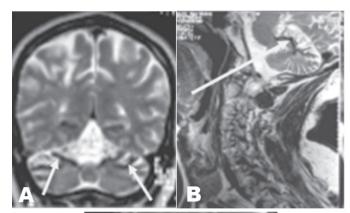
Showing black rimmed hypointensity in the superior cerebellum due to hemosiderin deposits on the (A) T2 coronal and (B) T1 sagittal MRI views, (C) Showing postoperative T2, sagittal MRI views three months later with less conspicuous signal change in the superior cerebellum.
